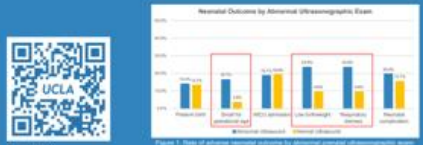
Rate of adverse neonatal outcomes by abnormal prenatal ultrasonographic scan.
